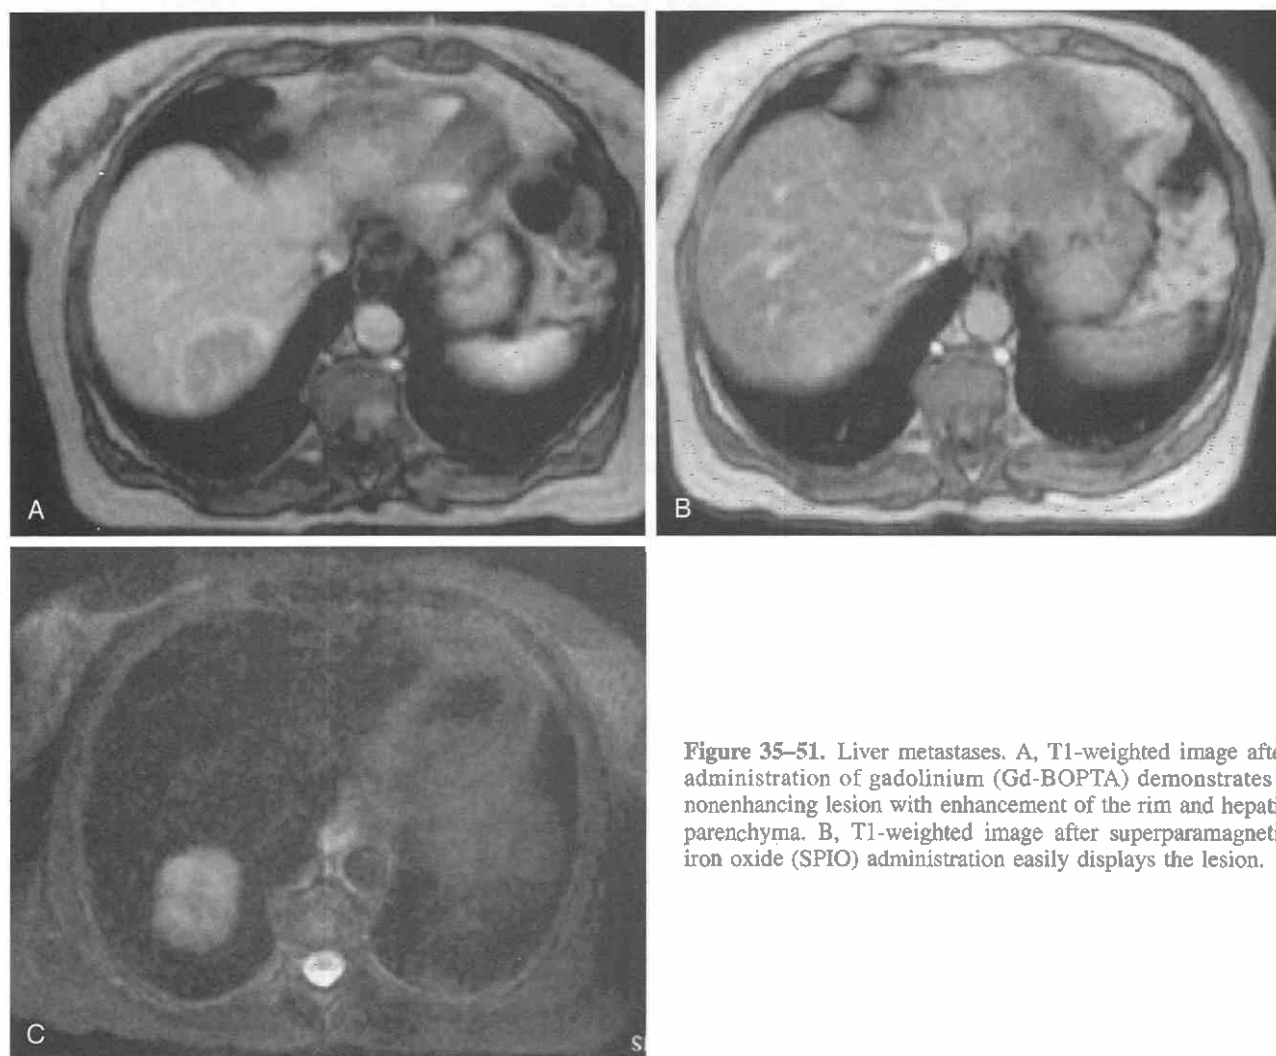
Liver metastases. *A*, T1-weighted image after administration of gadolinium (Gd-BOPTA) demonstrates a nonenhancing lesion with enhancement of the rim and hepatic parenchyma. *B*, T1-weighted image after superparamagnetic iron oxide (SPIO) administration easily displays the lesion.
